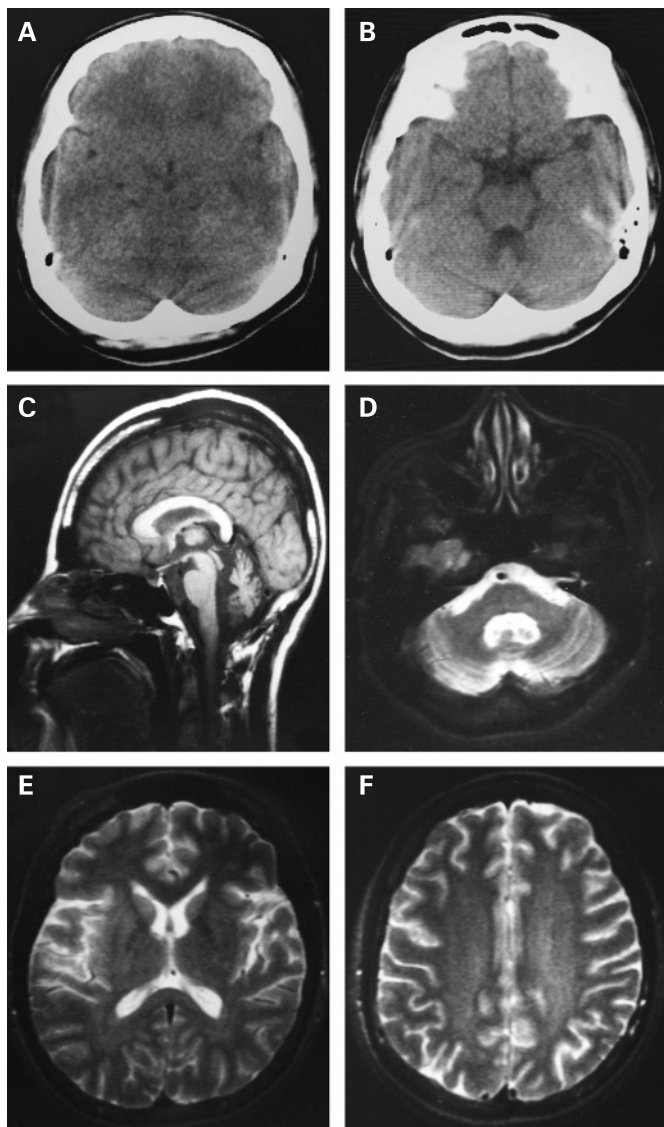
Representative CT and MRI of patient 4. (A) CT image acquired 3 days after intoxication showing obliteration of the fourth ventricle and sulcal marking in the posterior fossa suggesting swelling of intracranial structures. (B) CT image taken at 6 months showing widening of the cisterns and mild cerebellar atrophy. (C, D) T₁-weighted sagittal MRI (TR = 500, TE = 30) and T₂-weighted axial image (TR = 2500, TE = 80) taken 1 year later reveal severe atrophy of the cerebellar vermis and hemispheres. (E, F) T₂-weighted axial images showing no abnormality in the basal ganglia. Cortical atrophy was very mild in comparison with the cerebellar atrophy. Diffuse subcortical white matter lesions were also found but are less prominent than those of CO poisoning (supplementary fig 1).
